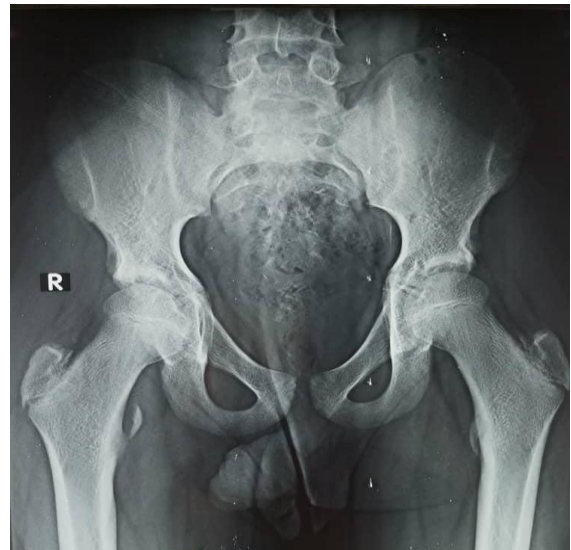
Anteroposterior radiograph of the pelvis showing an avulsion fracture of lesser trochanter on the right side.
